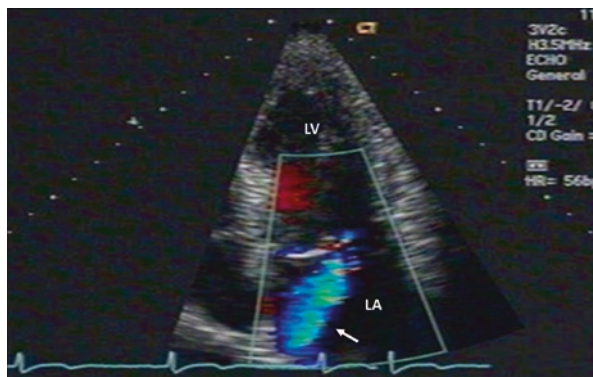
Papillary muscle rupture. (a) Apical four-chamber view showing ruptured head of the papillary muscle (arrow). (b) Apical three-chamber view with color Doppler demonstrating severe mitral regurgitation with large PISA radius. PISA Proximal isovelocity surface area
